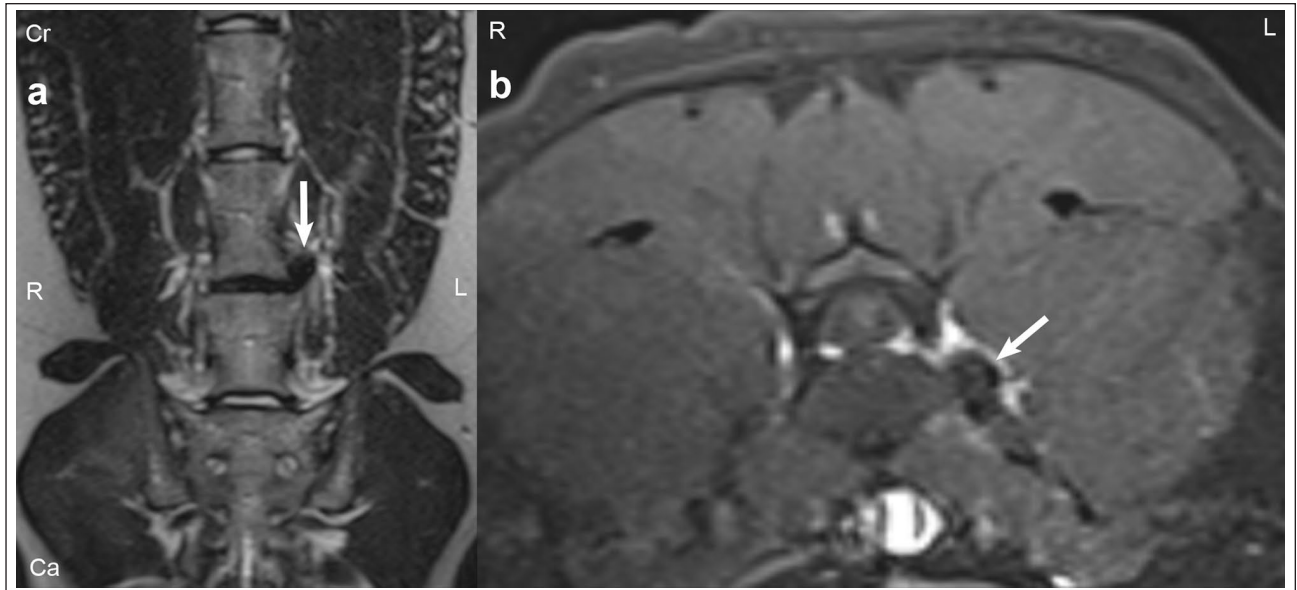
(a) Dorsal T2-SPACE MRI of the lumbosacral spine showing a large volume of low-signal-intensity disc material (white arrow) that has herniated laterally to the left intervertebral foramen. (b) Transverse T1 post-contrast MRI of the lumbar spine at the L6-7 intervertebral disc space demonstrating T1-hypointense material (white arrow) lateral to the left annulus fibrosus and the left intervertebral foramen, consistent with left far lateral intervertebral disc extrusion
